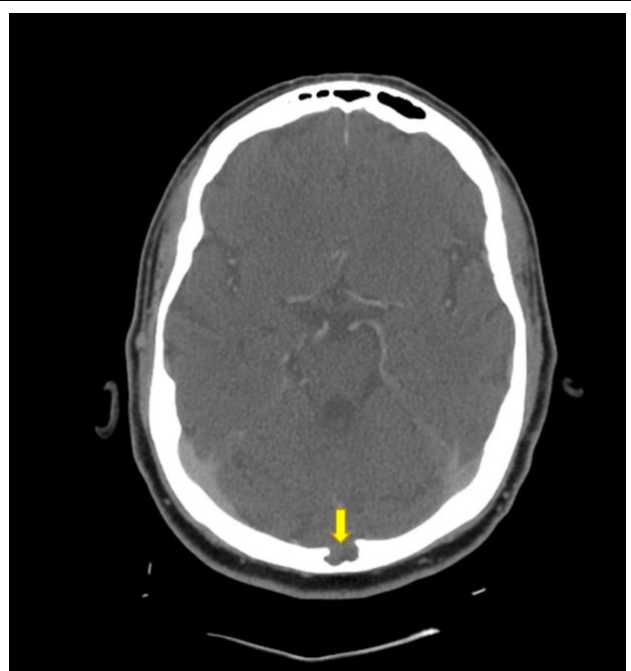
CT venogram head with contrast. Focal lobulated area of bony scalloping along the inner table of the midline occipital calvarium measuring 12 mm (arrow) compatible with an arachnoid granulation.
